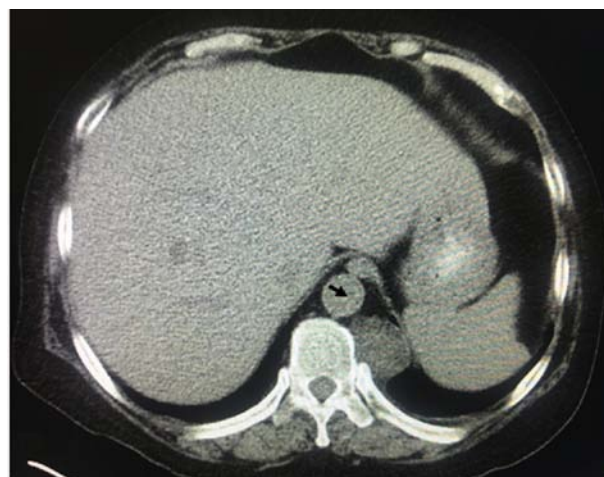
A scan of a 49-year-old female patient with leukemia presenting with lower paravertebral masses using chest computed tomography (mediastinal window; an axial view of the chest with emphasis on the mediastinum). The arrow indicates the aorta. The bilateral masses (adipose tissue) present in the paravertebral regions.
